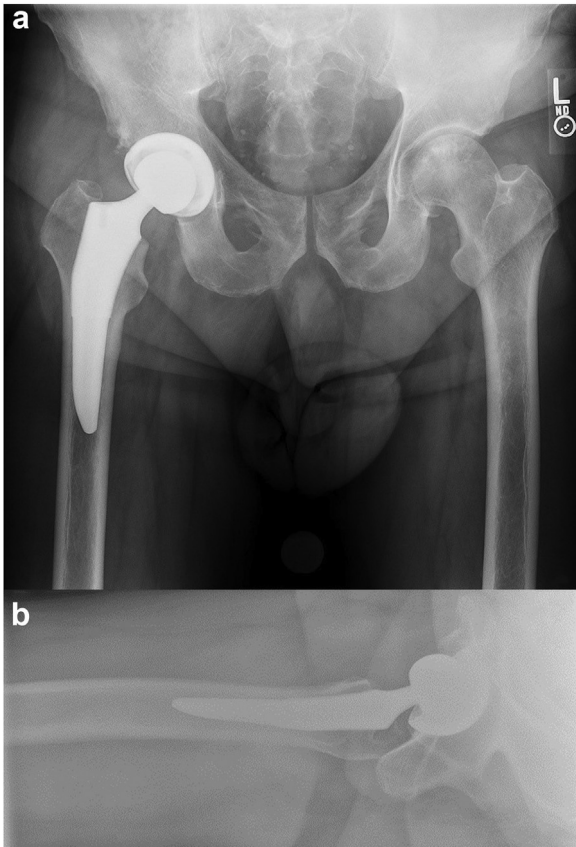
Postoperative radiographs 4 weeks after surgery: anteroposterior (AP) view (a) and cross-table view (b) show a well-positioned THA with restoration of leg lengths (LLD = 5 mm) and adequate Anteversion on cross table lateral view of 39 degrees.
